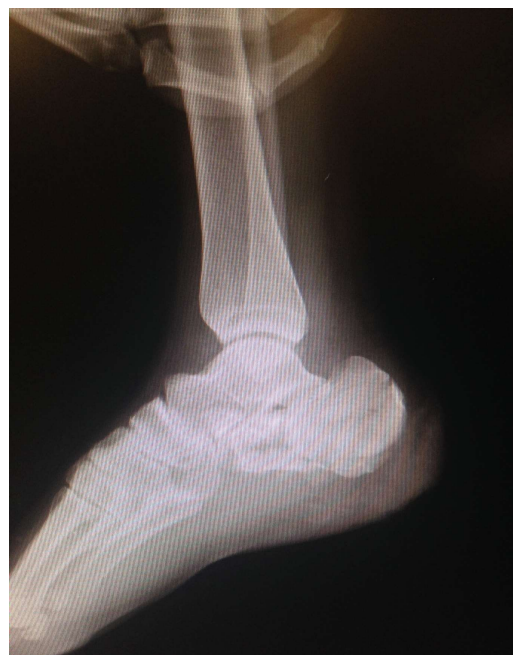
A 32 year-old male patient with calcaneus fracture due to fall from height. His preoperative lateral radiographic view.
